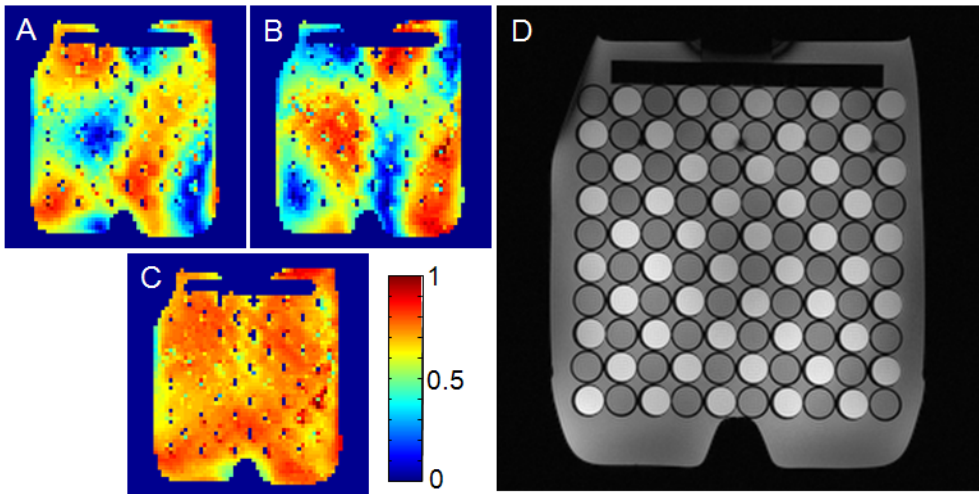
(A) and (B) show relative B1 maps of two inhomogeneous shim sets calculated using the homogeneity criterion given in Eq. 1. (C) shows the RSS combination. (D) shows the resulting T1-weighted TIAMO image with correct contrast.
